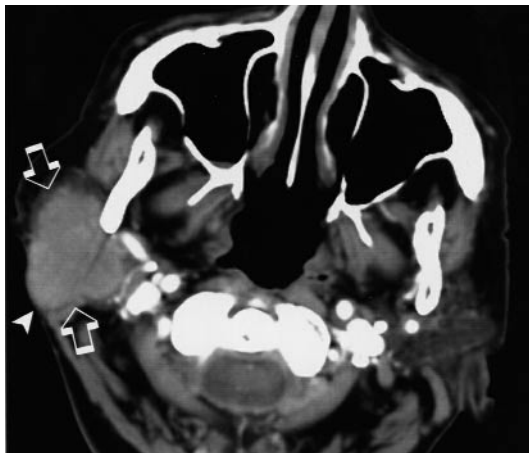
Axial computed tomography (CT) scan of a 65-year-old patient with B-cell non-Hodgkin's lymphoma of the parotid gland involving superficial and deep lobes, and overlying skin (arrow head). Notice the infiltrative ill-defined tumour margins (hollow arrows).
